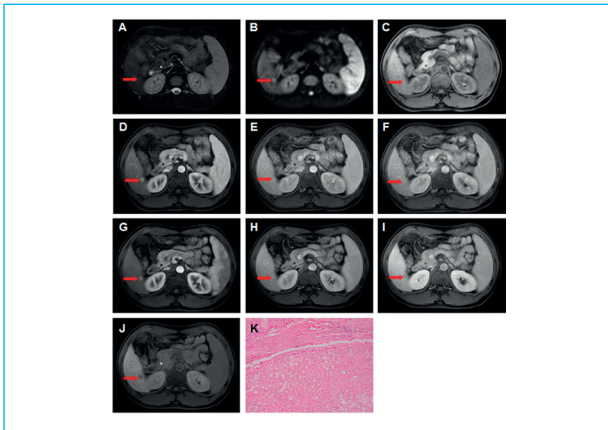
Small hepatocellular carcinoma in lower segment of right posterior lobe of liver. A: The lesion showed an equal signal on T2WI (arrow). B: The lesion showed a high signal on DWI (arrow). C: The lesion showed an equal signal on T1 with fat saturation (arrow). D: A significantly enhanced lesion (arrow) was showed in the arterial phase (Gd-DTPA). E, F: The equal signal of the was showed unclearly (arrow) in the portal venous phase and delayed phase (Gd-DTPA). G: A significantly enhanced lesion (arrow) was showed in the arterial phase (Gd-EOB-DTPA). H: The lesion with equal signal was showed in the portal venous phase. I-J: The lesion with a low signal was showed in 3 minutes delayed phase and 20 minutes delayed phase, and the boundaries were clear (arrow). K: The pathology confirmed that the lesion was a moderately differentiated hepatocellular carcinoma.
